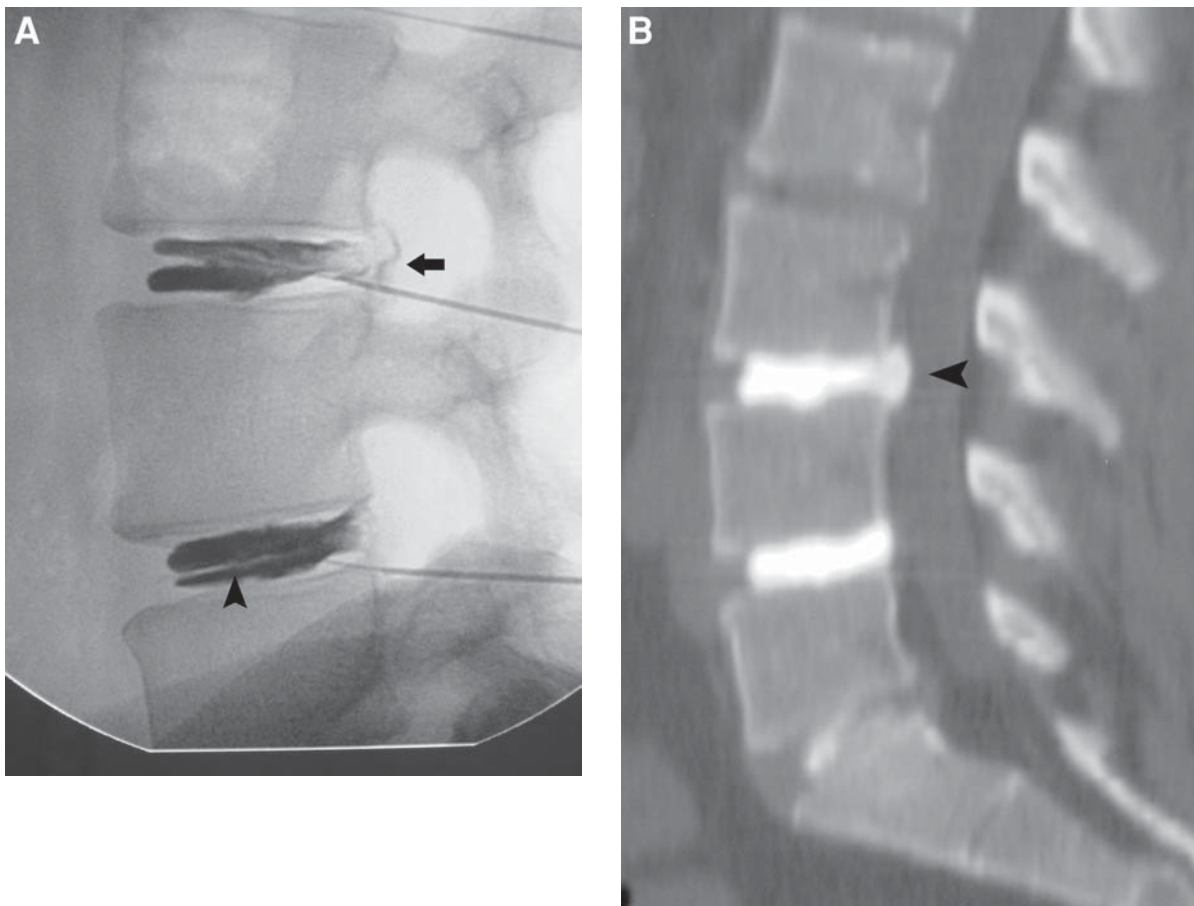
(A) Lateral image from a diagnostic discogram showing contrast extending into the ventral epidural space at the L3–4 disc (*arrow*). The contrast extends through all layers of the posterior annulus. This represents a grade 5 radial tear. Also note the grade 3 tear at L4–5. The contrast extends from the disc center to the outermost margin of the annulus posteriorly. Note the nuclear cleft (*arrowhead*). The bilaminar or “hamburger bun” appearance can be seen in a mature disc and if seen in isolation is a normal finding. (B) Sagittal CT reconstruction. Again note the grade 5 tear (*arrowhead*) at L3–4 and the grade 3 tear at L4–5.
